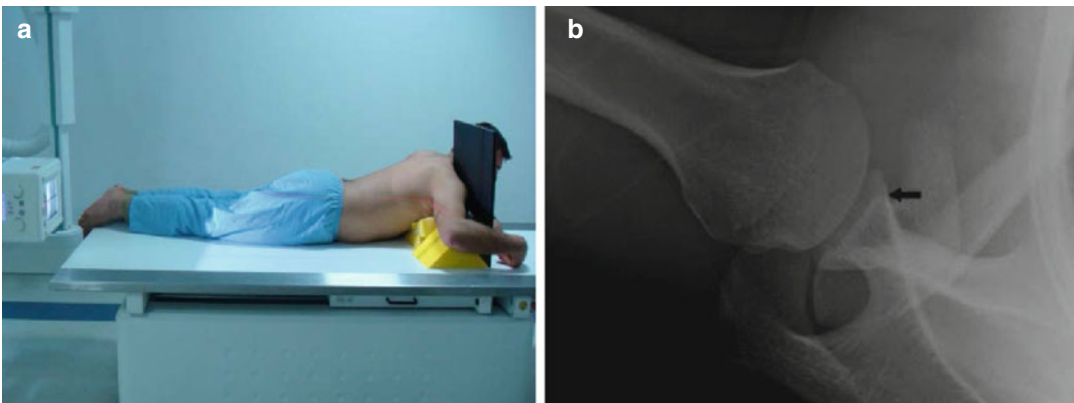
(a) Position of the patient and x-ray device during the West Point radiography. (b) Image of west point radiography. Arrows show location of Bone Bankart Lesion
